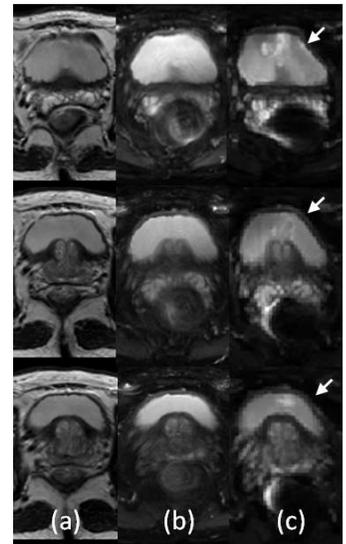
(a) T2-w images; (b) b0 images of VDS-DWI; (c) b0 images of EPI-DWI.
